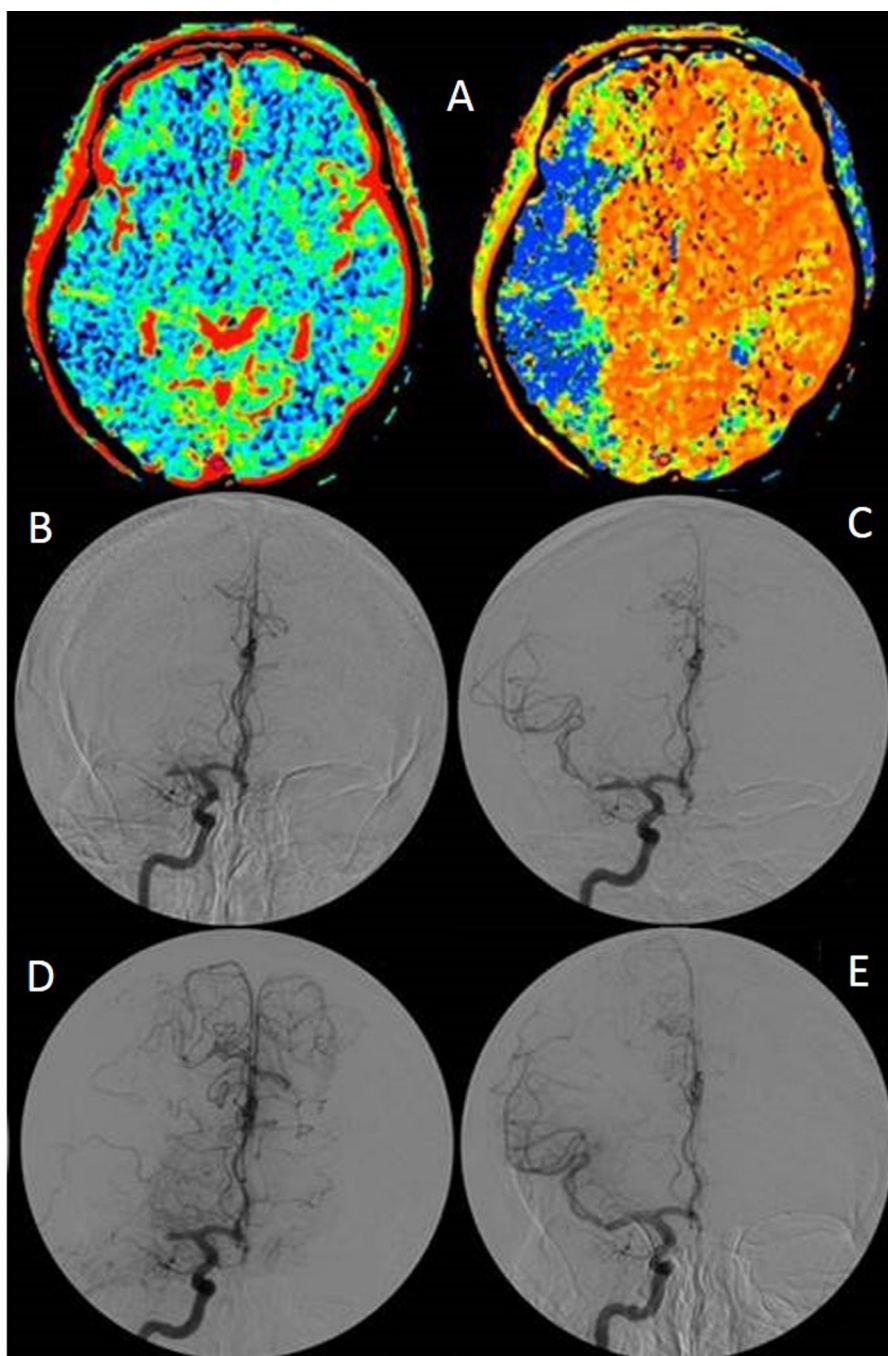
(A) Perfusion CT images showing a significant cerebral blood volume-mean transit time mismatch in the right middle cerebral artery (MCA) M1 field. (B) Angiography before intervention confirming the occlusion of the right MCA stem. (C, D) Consecutive incomplete stent retriever thrombectomies resulted in early reocclusion. (E) Angiography after microstent deployment in the right MCA M1 segment.
